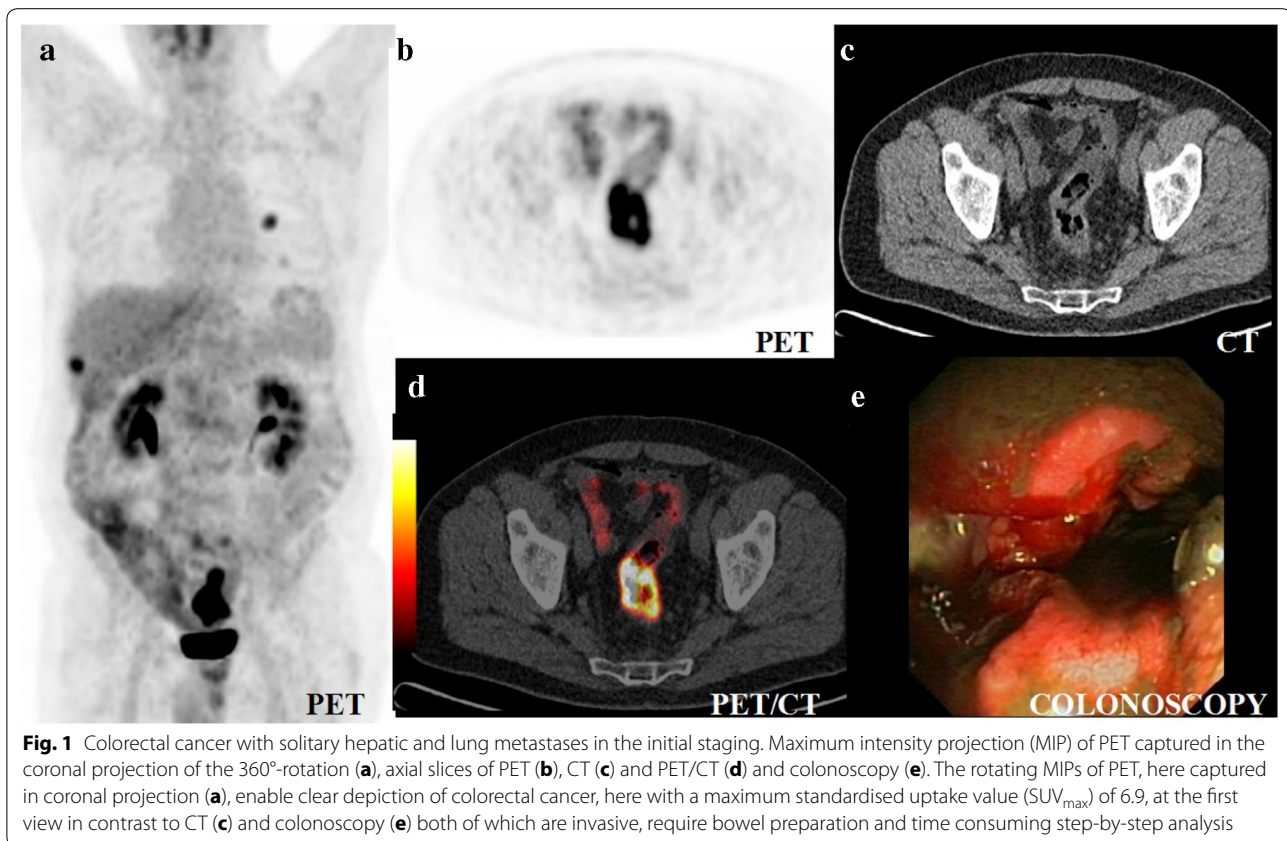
Colorectal cancer with solitary hepatic and lung metastases in the initial staging. Maximum intensity projection (MIP) of PET captured in the coronal projection of the 360°-rotation (a), axial slices of PET (b), CT (c) and PET/CT (d) and colonoscopy (e). The rotating MIPs of PET, here captured in coronal projection (a), enable clear depiction of colorectal cancer, here with a maximum standardised uptake value (SUV_{max}) of 6.9, at the first view in contrast to CT (c) and colonoscopy (e) both of which are invasive, require bowel preparation and time consuming step-by-step analysis
